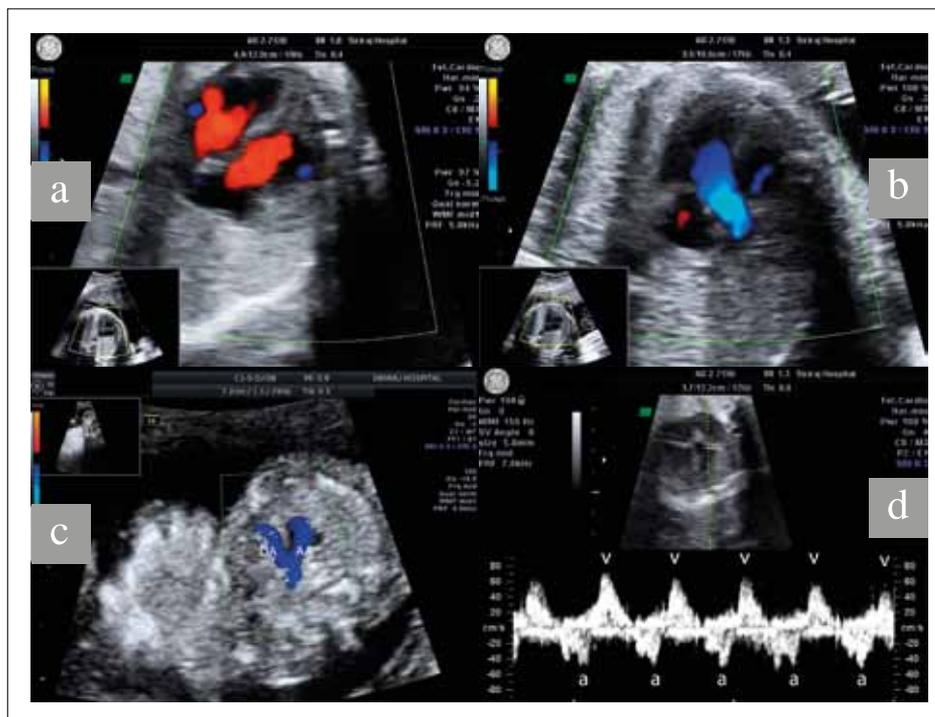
Normal Doppler ultrasound.
